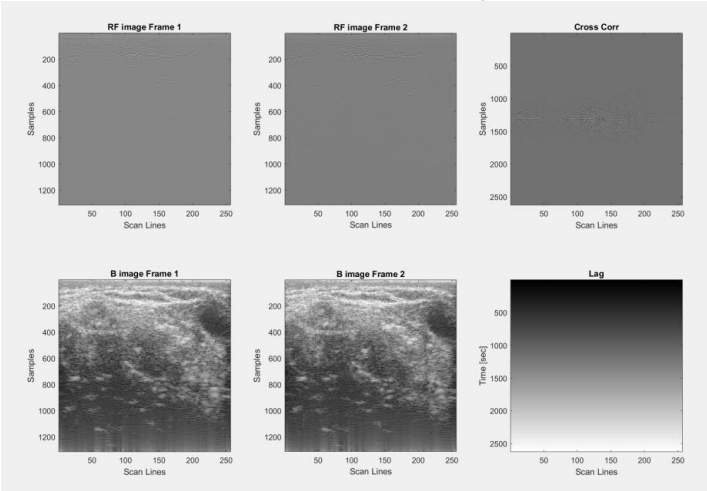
RF obtained images from BK ultrasonix, log compressed images and cross correlation of image by scan line provides frame-to-frame structural position changes, computed in Matlab.
